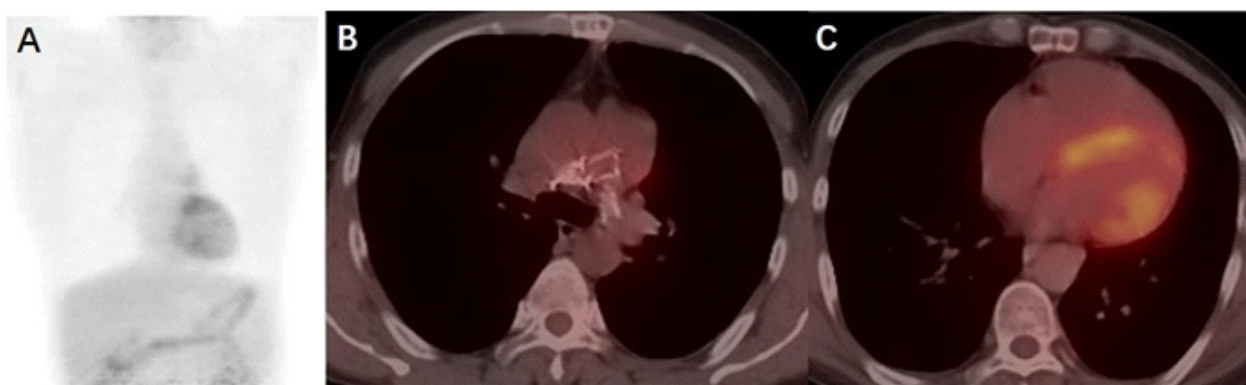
The patient recovered 2 years later after receiving the steroid treatment and a MPA stent implantation. Thoracic ¹⁸F-FDG PET/CT showed the original hypermetabolic foci in the MPA disappeared completely and the secondary cardiac changes also restored (A-C).
